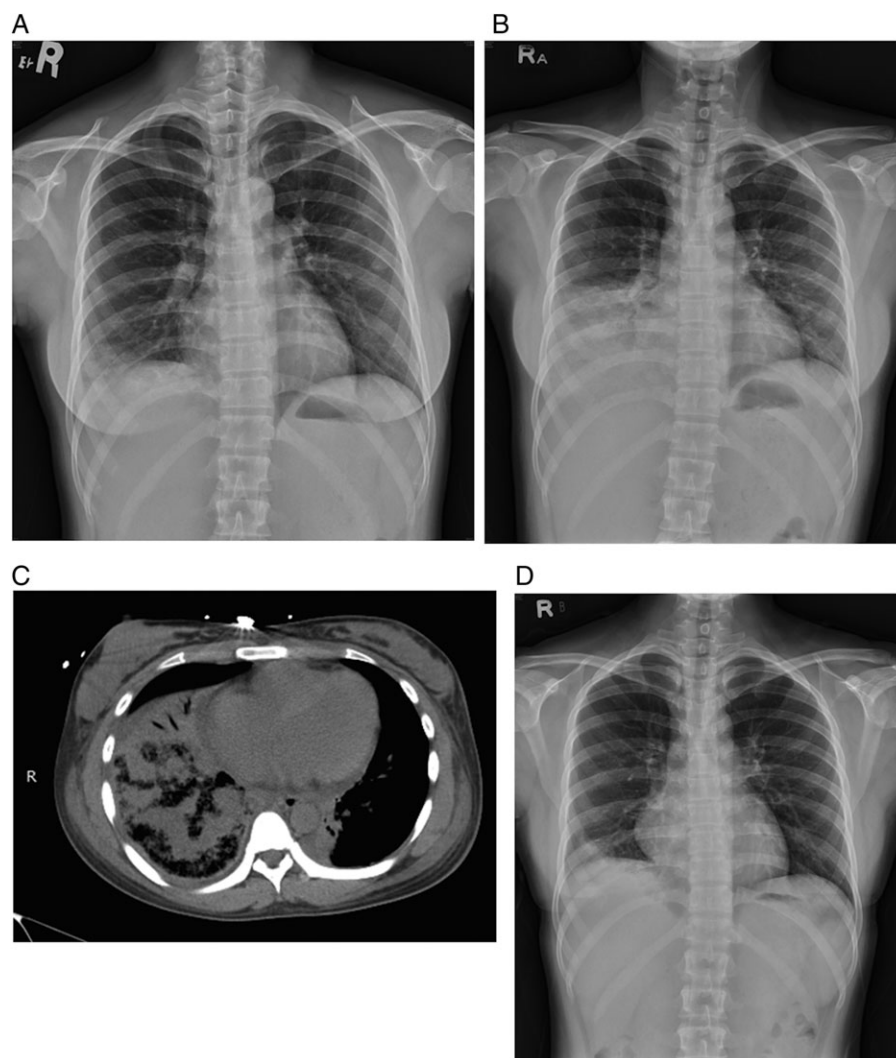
Chest images of the present case. (A) The chest radiograph (CXR) on initial presentation showed right lower lobe consolidation. (B) The CXR 2 days after initial presentation showed rapid progression of right lower lobe consolidation and new infiltrate in left lower lobe. (C) The chest computed tomography (CT) 2 days after initial presentation showed right lower lobe diffuse consolidation and alveolar infiltrate in left lower lobe. (D) The CXR 3 months after treatment showed nearly complete resolution of the lung consolidations.
